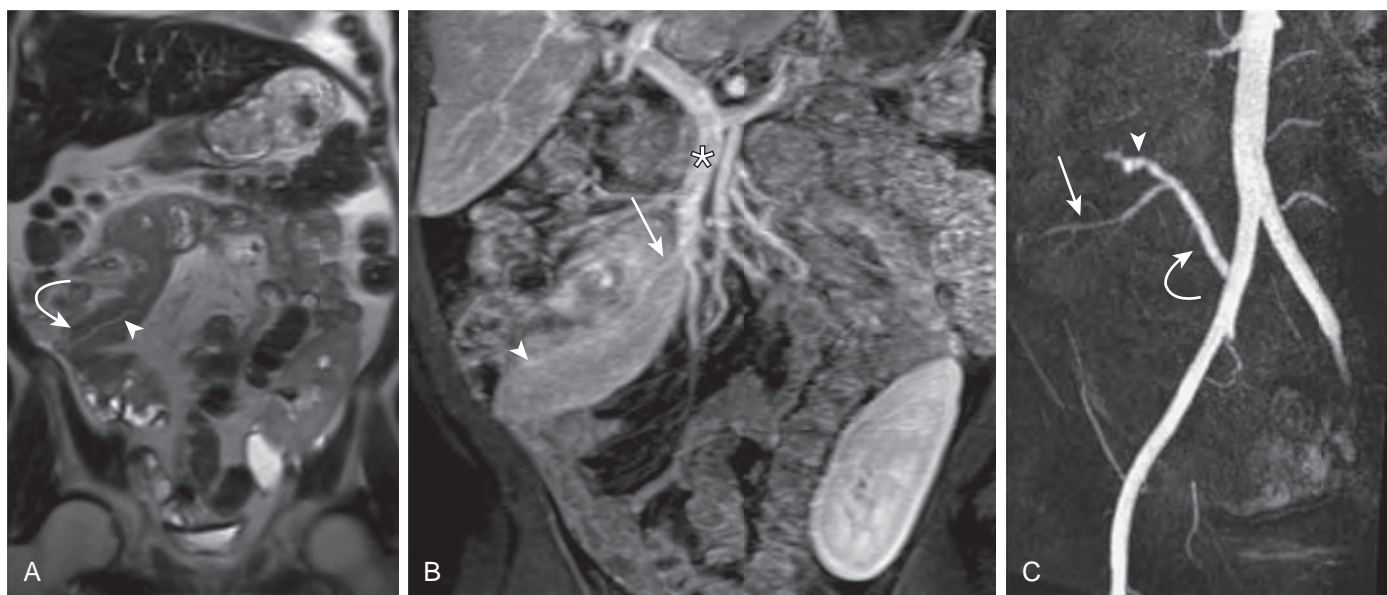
Normal MR appearance of pancreas transplant in different patients. A. Coronal half-Fourier acquisition single-shot turbo spin-echo (HASTE) T2-weighted MR image shows the pancreas transplant (curved arrow), which has signal intensity between that of muscle and fluid. A nondilated segment of pancreatic duct is visible (arrowhead). B. Coronal dynamic volume-interpolated breath-hold examination (VIBE) shows normal enhancement of the pancreas transplant (arrowhead), with a patent graft vein (arrow) draining into the recipient's superior mesenteric vein (asterisk). Note the normally enhancing left lower quadrant renal transplant. C. Maximum intensity projection shows a patent Y-graft artery (curved arrow) anastomosed to the right common iliac artery. Note the splenic (arrow) and superior mesenteric (arrowhead) branches. (From Vandermeer F, Manning MA, Frazier A, et al: *Imaging of whole-organ pancreas transplants*. *RadioGraphics* 32:411–435, 2012.)
